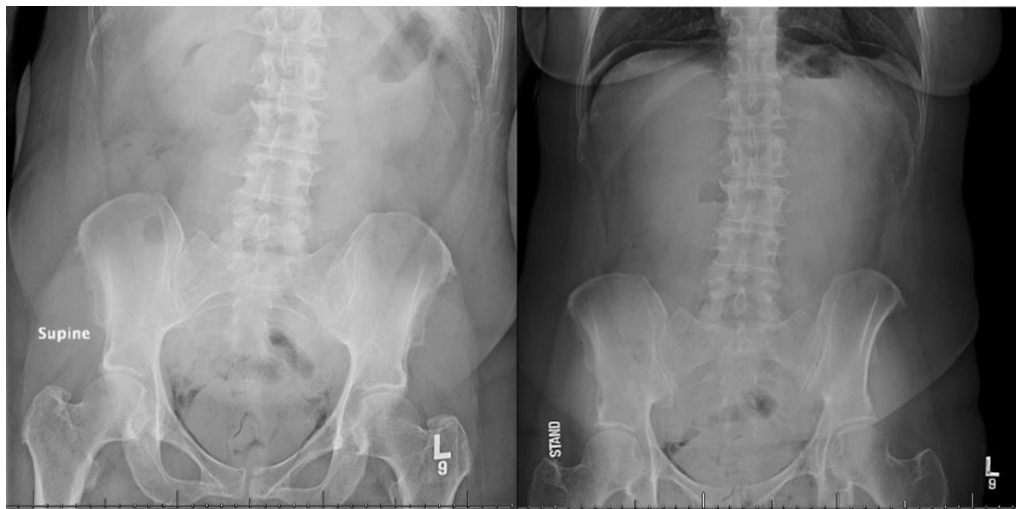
Hospital re-admission abdominal radiograph on post-operative day 2.
